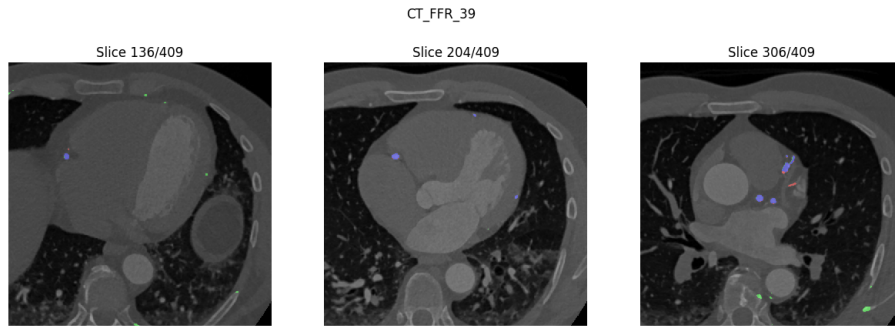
A selection of some of the CT slices of the BVNet3D model's best prediction of the coronary artery split-0, where the corresponding prediction is overlaid. The prediction is color-coded with blue=TP, green=FP, and red with low opacity=FN
